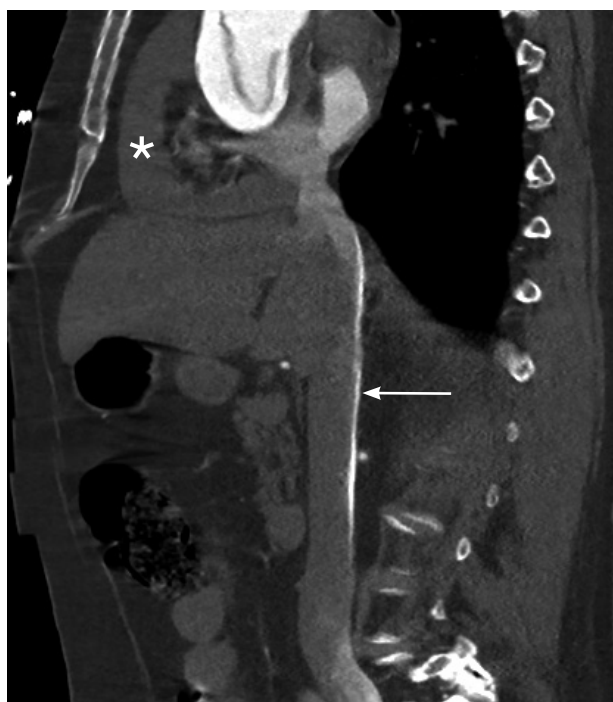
Sagittal section through the inferior vena cava on a computed tomography angiogram. Haemopericardium (asterisk) results in high pressure in the pericardium, preventing normal filling of the right atrium and ventricle, so diverting the contrast into the inferior vena cava (arrow).
